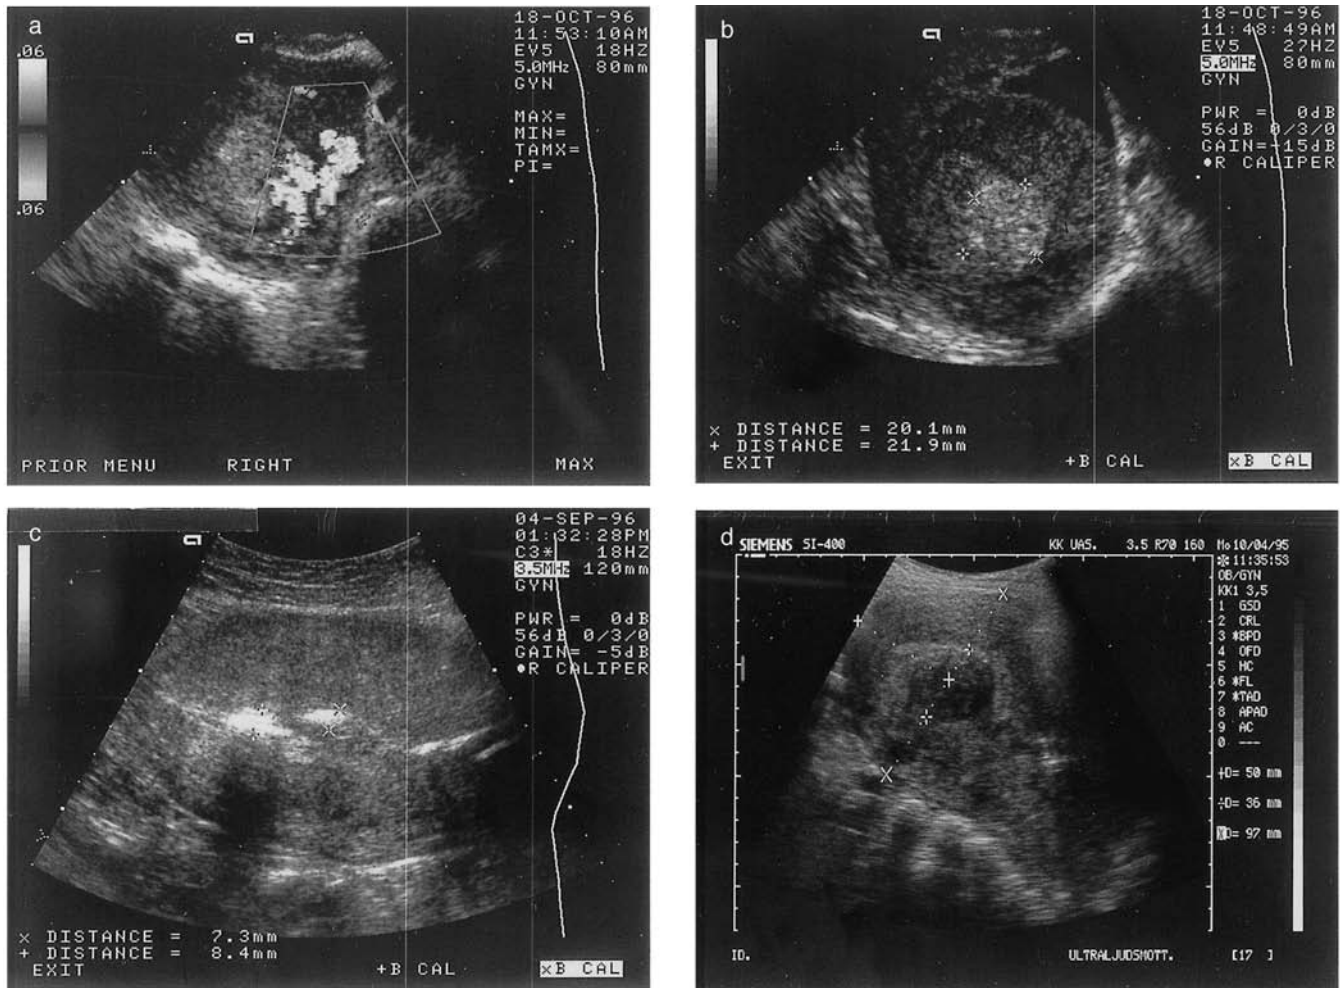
Puerperal abnormalities revealed by ultrasound: (a) retained placental tissue 2 days postpartum; (b) low-resistance blood flow on the side of the mass; (c) retained placental tissue 6 weeks postpartum; (d) a thin, echogenic endometrium soon after curettage.
